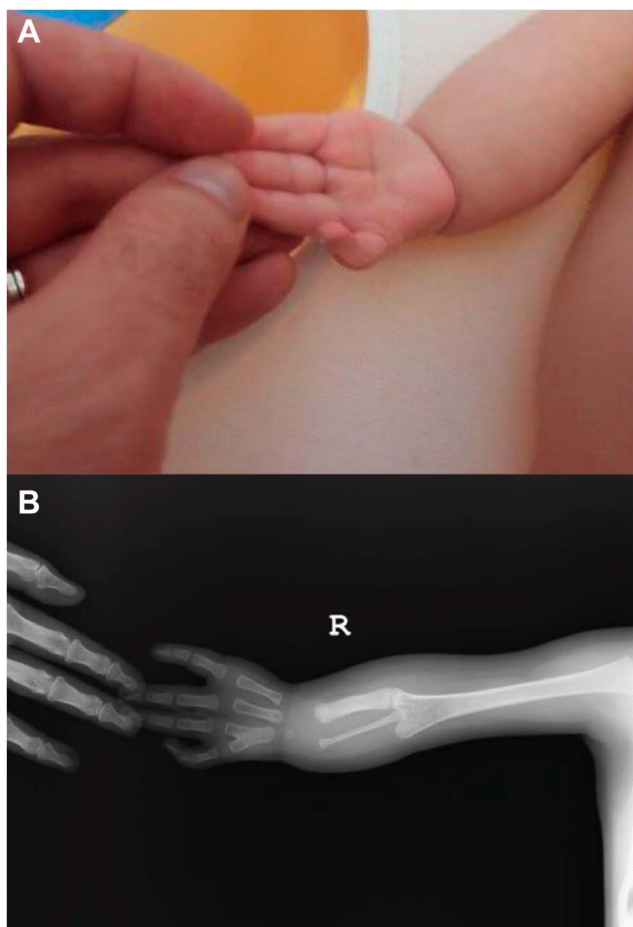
Extended right elbow and wrist and abducted index finger from the palmar site after positioning splint (a) and X-ray of the right arm from the dorsal site after positioning splint (b).
